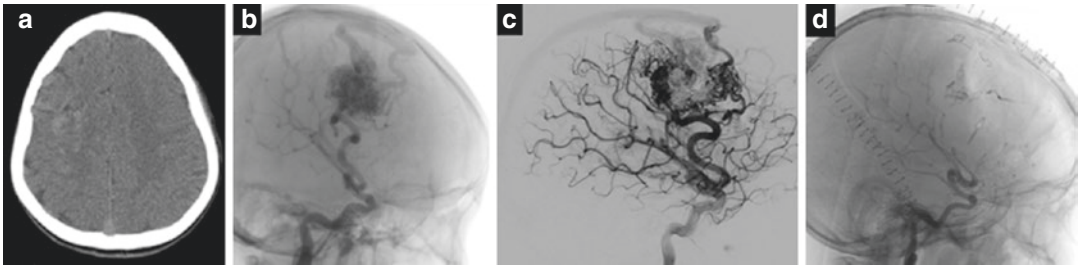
A 13-year-old boy presented with recurrent seizures. (a) Non-contrast CT showed a hyperdensity within the right frontal lobe, consistent with an unruptured AVM. (b) Diagnostic angiography showed a SM III
